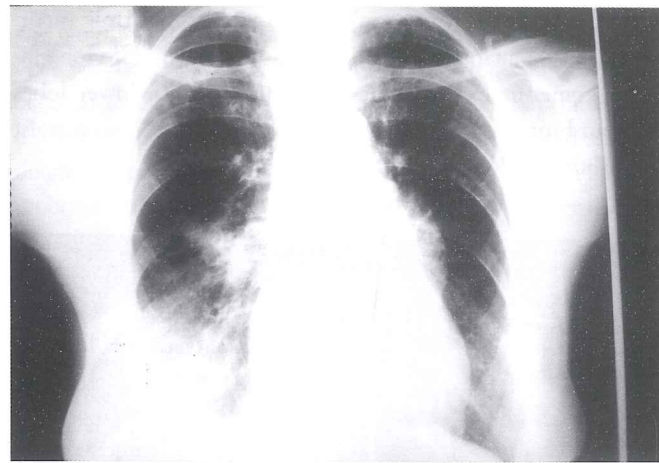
Previous chest x-ray (August, 2000) showing left hilar, right perihilar densities and right lower lobe consolidation.
